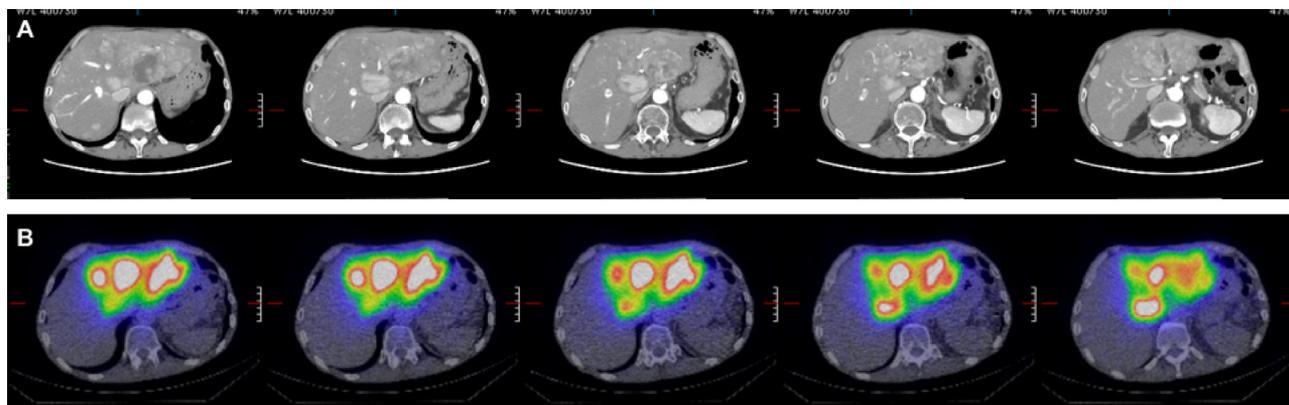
Treatment of primary hepatocellular carcinoma with ^{90}Y -microsphere radioembolization. (A) CT showing multifocal disease in the left lobe. (B) Post-treatment Bremsstrahlung SPECT/CT imaging showing localization of the ^{90}Y -labeled microspheres in the tumor within the left lobe, without uptake outside the liver.
